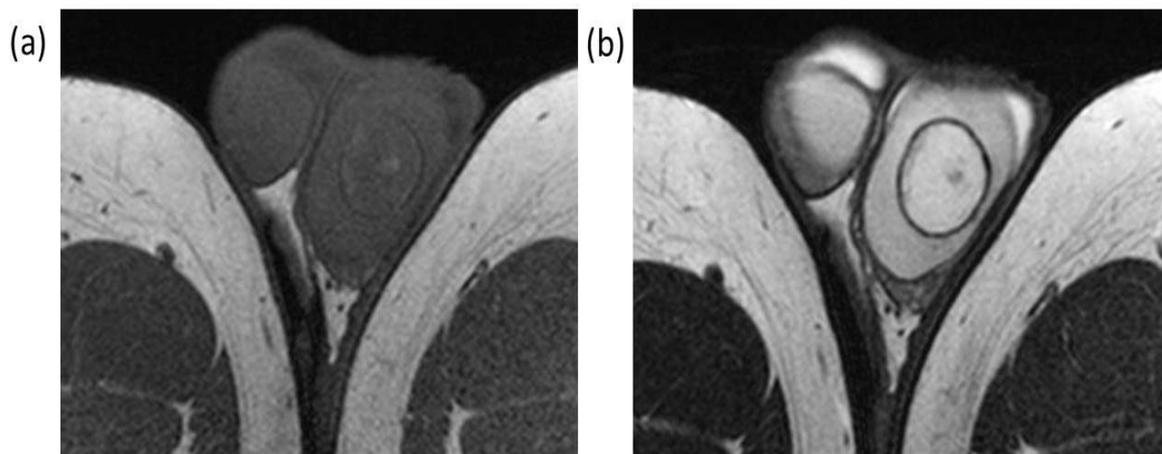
Magnetic resonance imaging showed a round tumor with distinct boundary between the tumor and the normal testicular tissue in the patient's left testis. (a) T1-weighted image. (b) T2-weighted image.
